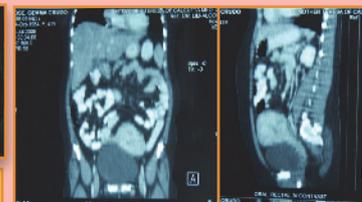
CT scan of the abdomen showed enhancing density in the uterus consider leiomyoma
